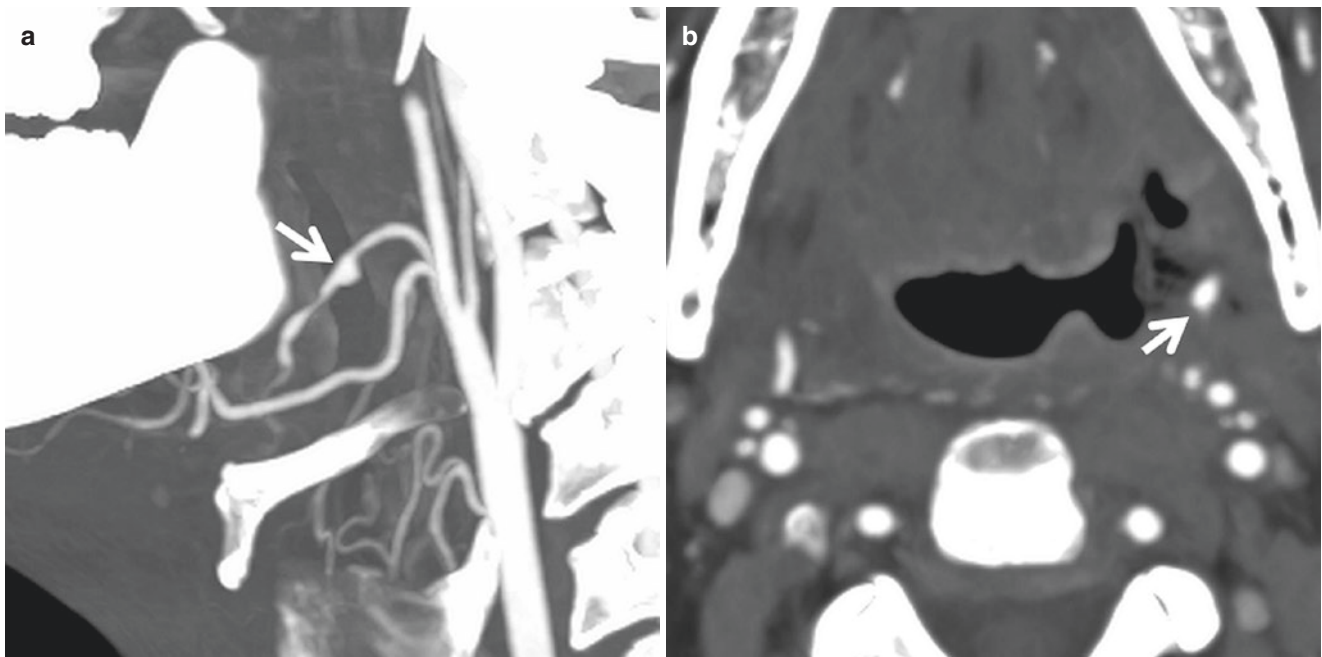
Carotid blowout syndrome from ECA branches. Patient with history of left base of tongue cancer status post radiation presents with hematemeses. (a) Sagittal CTA MIP image shows a pseudoaneurysm of left facial artery (*arrow*). (b) Axial CTA MIP shows the pseudoaneurysm (*arrow*) is within the treated lesion of left base of the tongue surrounded
